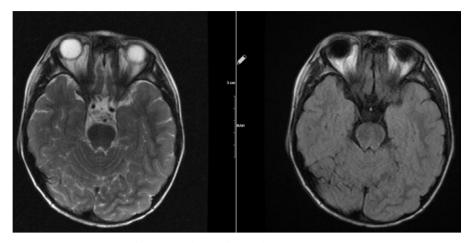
Normal T2 ve flair axial sequence on MRI.
